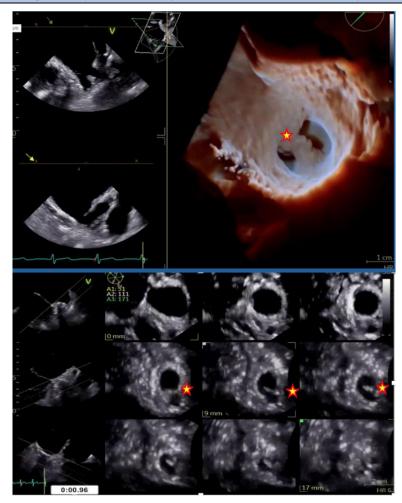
Multimodality transesophageal echocardiographic assessment of the mitral valve.
